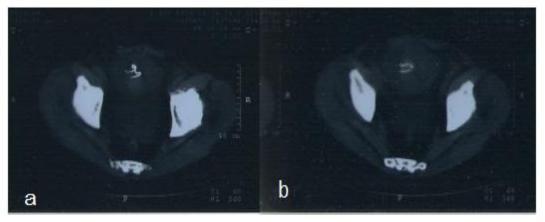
Axial abdominal computed tomography shows gossypiboma.
